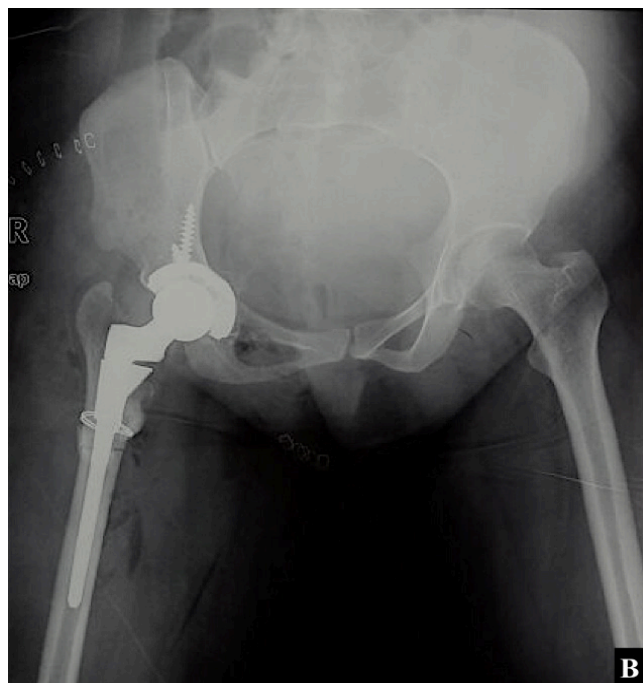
Immediate post-operative X-ray of pelvis in Antero-Posterior with both hips following total hip arthroplasty. The patient had to undergo sub-trochanteric shortening osteotomy as well as adductor tenotomy. There was no requirement of additional fixation. A prophylactic cerclage wire was applied during femoral preparation.
